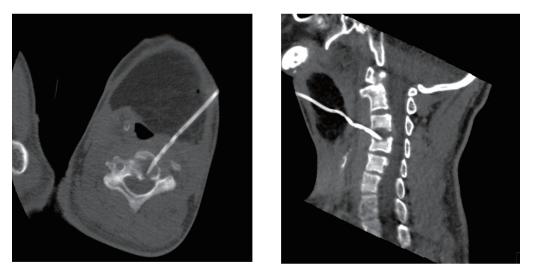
The tissue biopsy was performed by puncturing the intervertebral disc of C3 and C4 from the anterior cervix under CT guidance. The pus was drained using fine-needle aspiration, and the tube drain was placed.
